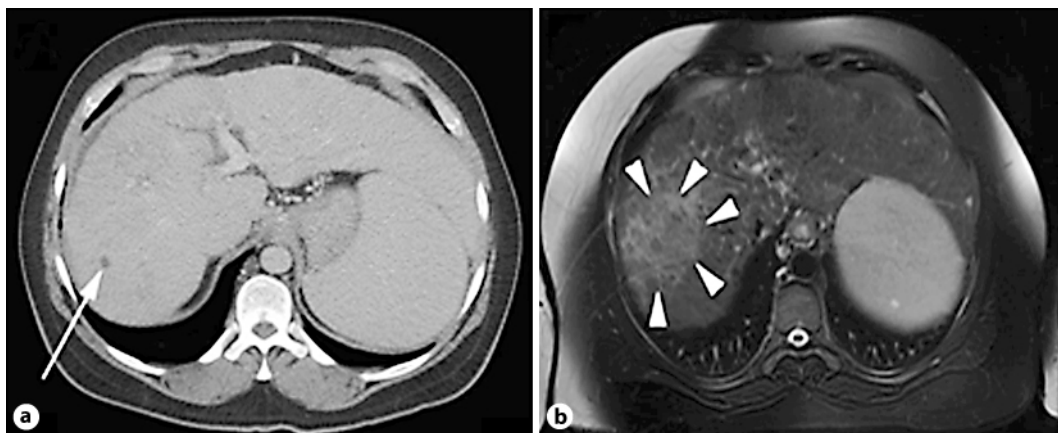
a CT revealing an 8-mm liver nodule (arrow). b Contrast-enhanced MRI showing a 10×8 cm enhancing mass in the right hepatic lobe, not seen with CT (arrowheads).
